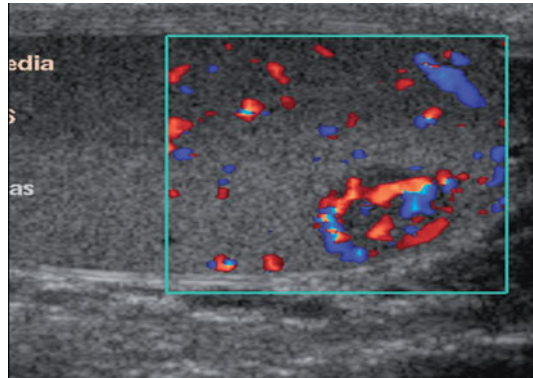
Seminoma. Lesion of around 2 cm appears hyper-vascular on color Doppler
